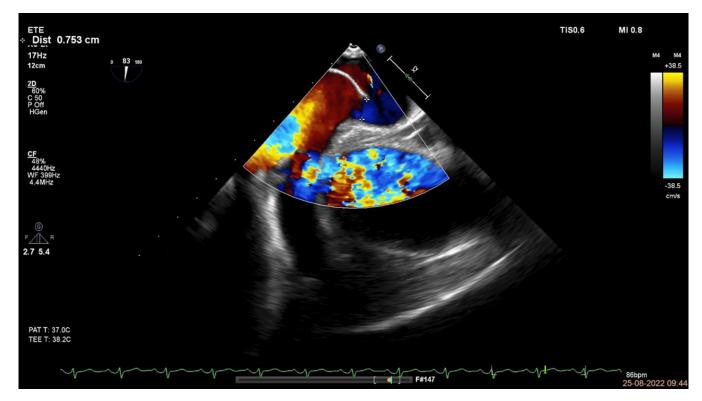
Transesophageal echocardiogram showing interatrial communication.
